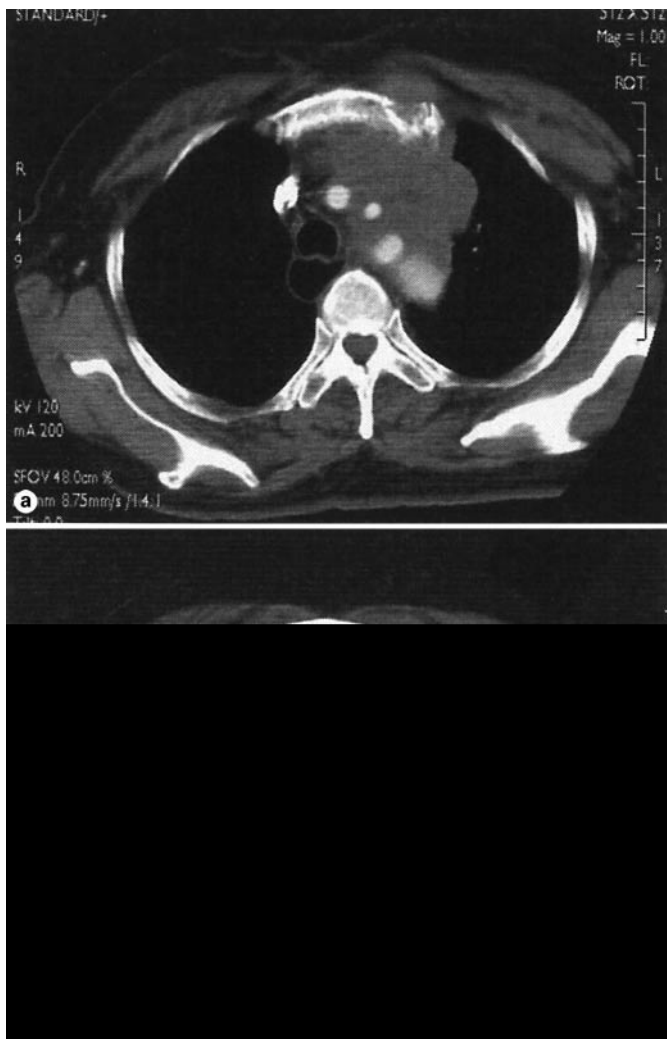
a CT scan showing an anterior mediastinal tumor (64 × 46 mm), extending to the ascending aorta, brachiocephalic trunk, left general carotid artery, left subclavian artery, and left supraclavicular fossa. b CT scan showing a residual anterior mediastinal tumor.
